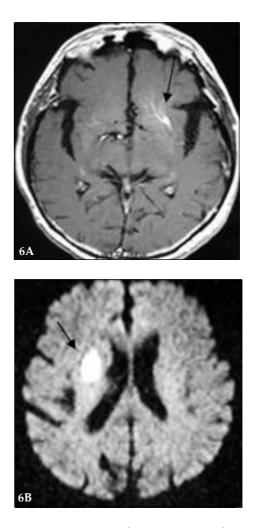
A) Axial Gd-enhanced T1-weighted MRI showing venous angioma next to the left caudate nucleus. B) Axial Diffusion- Perfussion MRI showing hyperintense area next to the right caudate nucleus.
